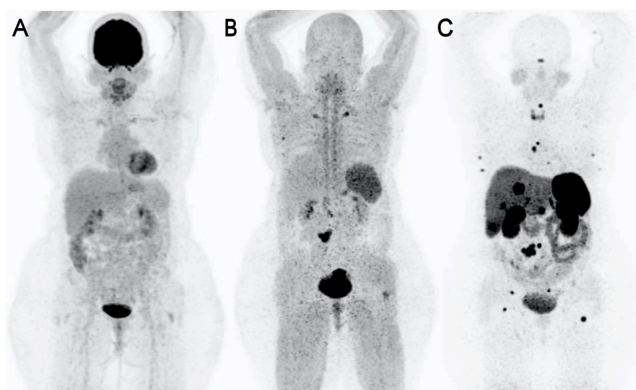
Cancer integrin imaging with ^{68}Ga]-Ga-Trivehexin PET/CT for a patient with breast cancer and neuroendocrine neoplasm: a case both ^{18}F -FDG PET/CT and ^{68}Ga]-Ga-DOTATATE positive but integrin $\alpha\text{v}\beta 6$ negative lesion on ^{68}Ga]-Ga-Trivehexin PET
